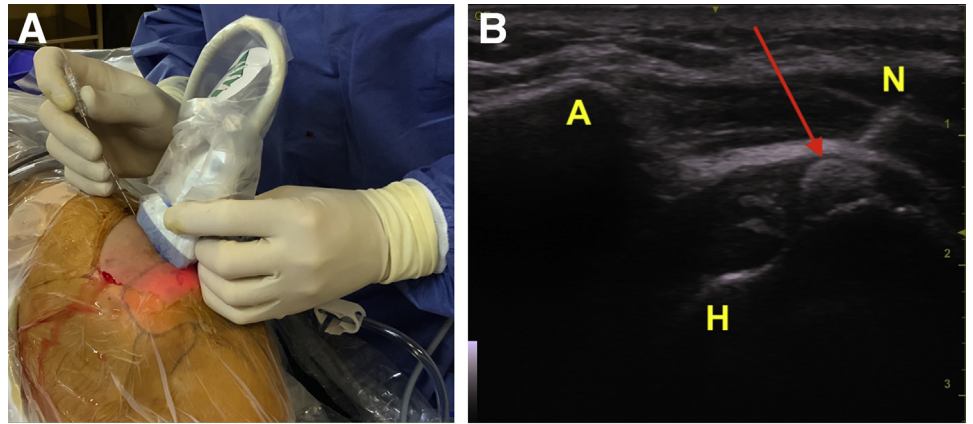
Right shoulder in a 52-year-old female patient in lateral position. Longitudinal arthroscopic ultrasound-guided needling: (A) placement of a needle parallel to the main axis of the probe. (B) Ultrasound view of the entire pathway of the needle (arrow: calcification). (C) Comparison of the entry point on the superficial surface of the tendon between a parallel and perpendicular approach. (A, acromion; H, humeral head; N, needle.)
